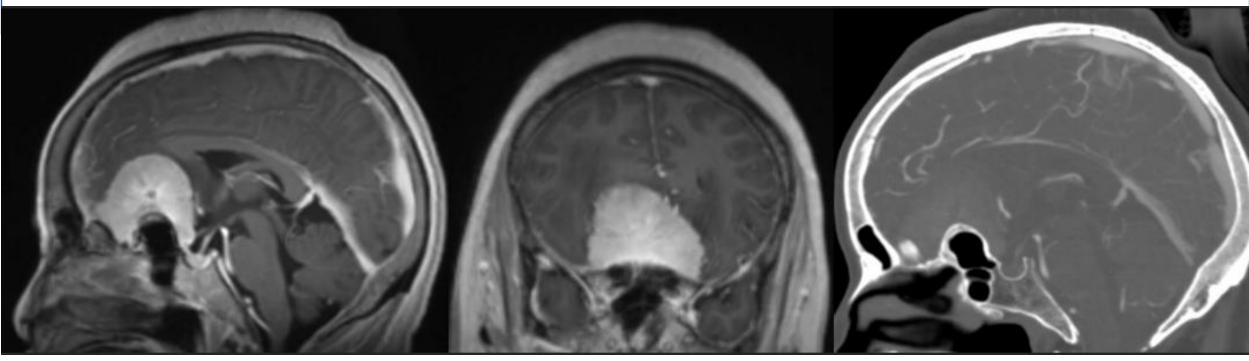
Sagittal/coronal MRI, sagittal CTA showing large anterior skull base meningioma with hyperostosis and bony remodeling of planum sphenoidale
